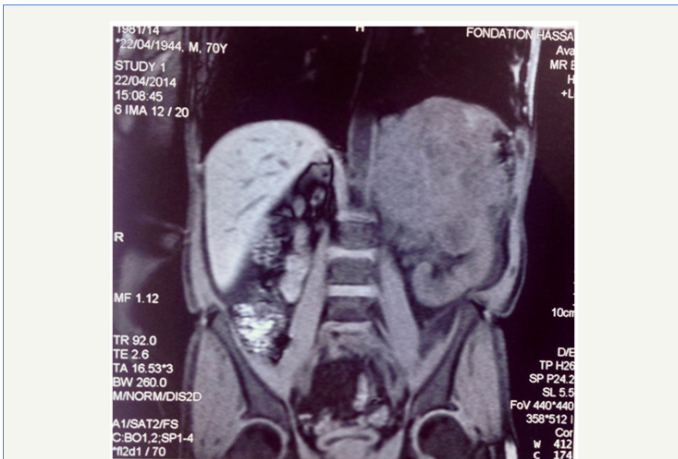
Sagittal magnetic resonance imaging showing a left renal process, infiltrating the renal sinus and the renal pedicle. The VCI remains free and of normal caliber.
